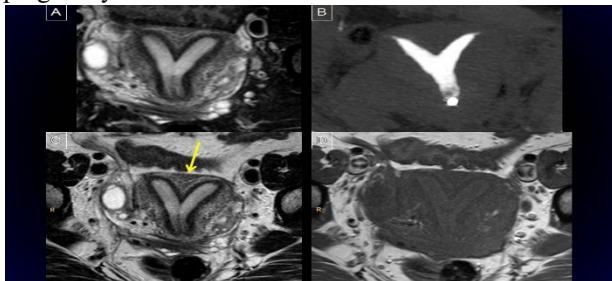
MRI showing partial septate uterus CASE PRESENTATION
